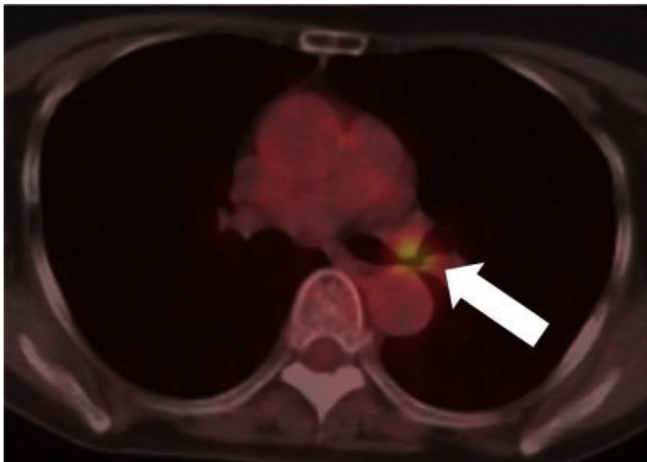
Positron emission tomography/computed tomography revealing higher accumulation of ^{18}F -fluoro-2-deoxy-D-glucose in the lumen of the left main bronchus (maximum standardized uptake value = 4.1) coinciding with tumor (arrow).
